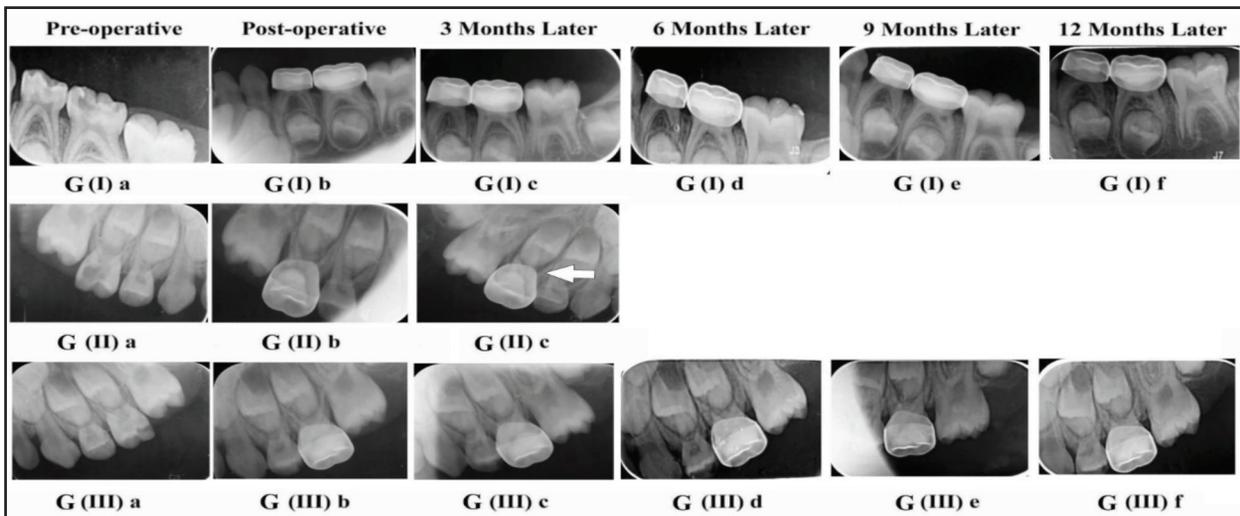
Radiographic showing Biodentine pulpotomy on lower left D&E (G1), Simvastatin pulpotomy on upper right E (GII), and combination of Biodentine and Simvastatin pulpotomy on upper left E (GIII).
